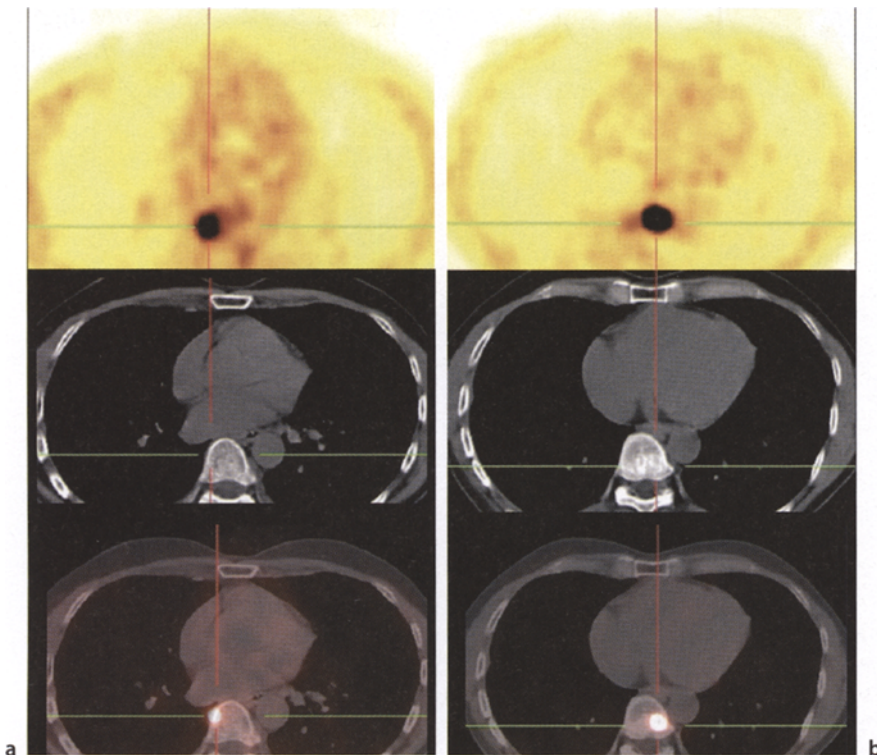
Vertebral bone metastases of ileum carcinoid. Osteoblastic, receptor-positive lesion on CT in one thoracic vertebra (a), whereas another lesion, with strong, focal SMS-receptor expression on Ga-68 DOTA-NOC-PET, is invisible on CT scan (b)
